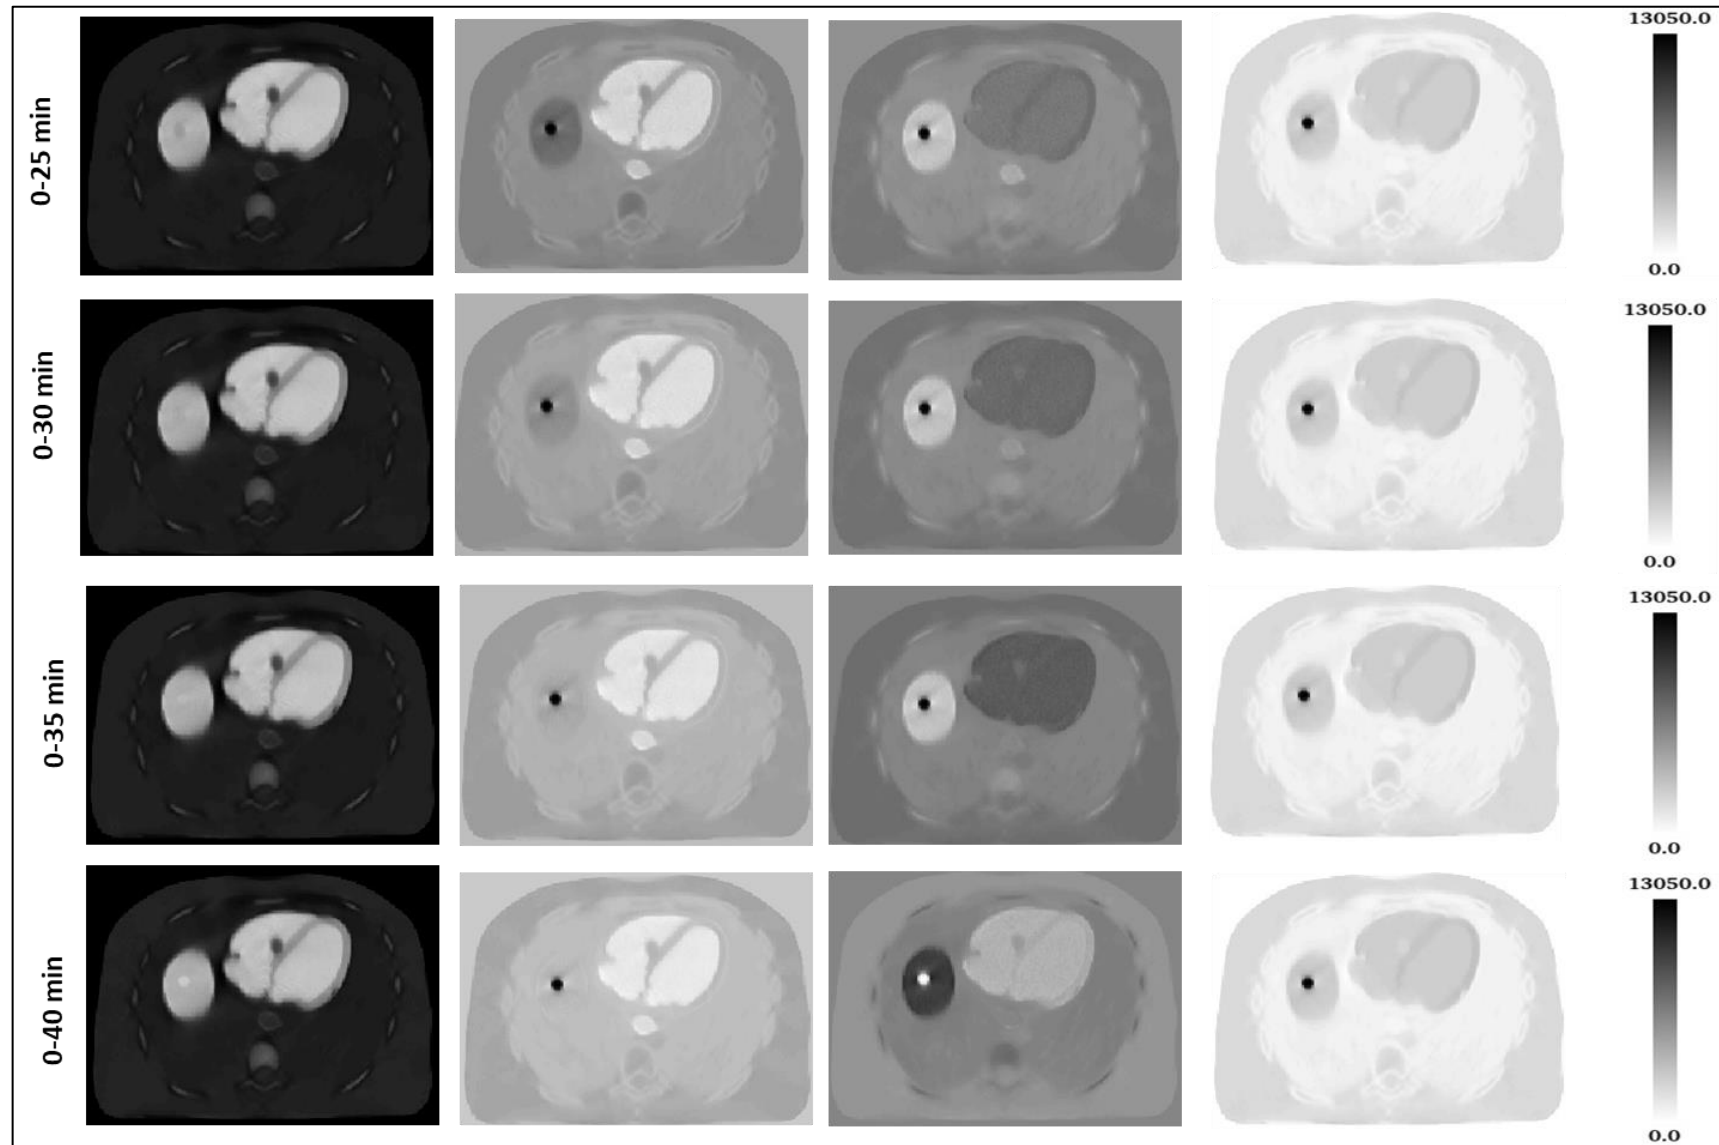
b Transverse slices obtained by the PCA method at 0-25, 0-30, 0-35 and 0-40 time intervals showing ^{18}F -FDG uptake in lesions and other tissues. The SUM images were generated at 35-55 min intervals as described above.
